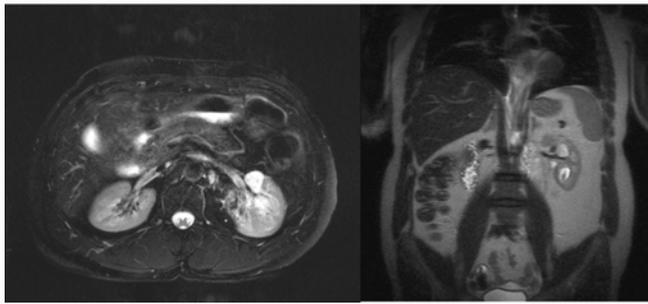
Renal MRI images in June 2021 before surgical resection of metachronous solitary fibrous tumors.
